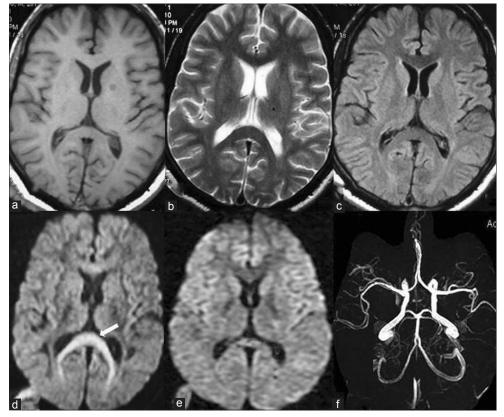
Magnetic resonance imaging and magnetic resonance angiography (Brain) of case 1, with refractory epilepsy, showing normal, axial, T1-weighted (a), T2-weighted (b) and fluid attenuated inversion recovery (c) images with increased signal intensity of the entire splenium of corpus callosum ("Boomerang sign") on diffusion-weighted image (d); repeat diffusion-weighted image (e), done at 6 months, showing complete resolution of abnormal signals involving the splenium. Magnetic resonance angiogram (f) did not reveal any abnormality
